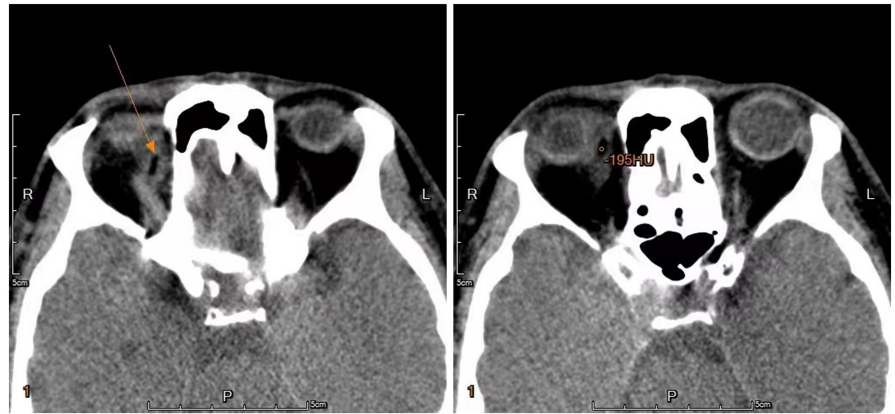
CT scan showing the strip low-density shadow in the lateral orbit, small flake low-density shadow around foreign body.
